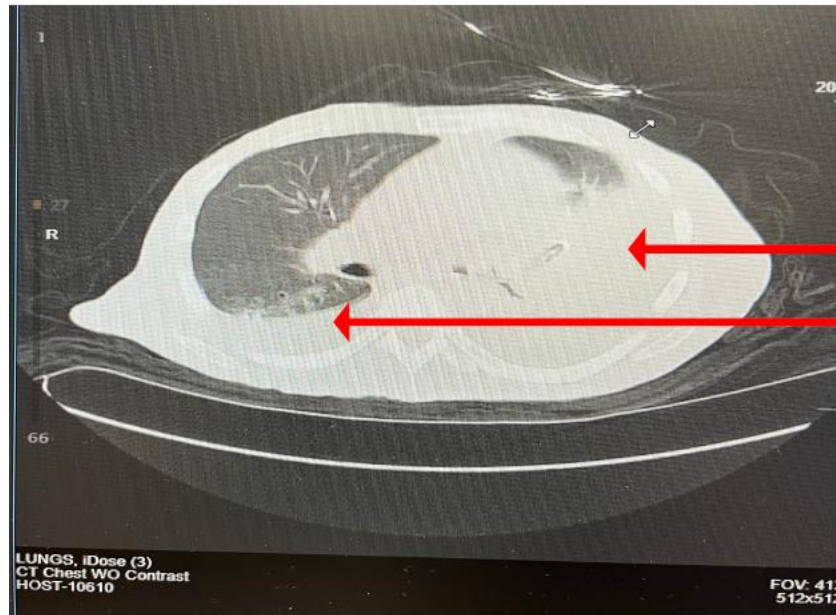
Axial non-contrast CT chest demonstrating a large left-sided pleural effusion and a moderate right-sided pleural effusion.
